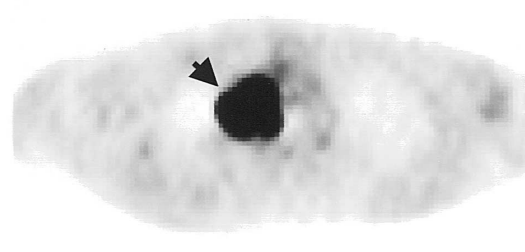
a) Contrast enhanced axial CT scan image at the level of main pulmonary artery bifurcation reveals right hilar adenopathy (*short arrow*). A small hyperdense subcutaneous nodule (*long arrow*) is also present in the right posterior chest wall. b) Corresponding focal intense FDG uptake is seen in both locations on an axial PET scan image (*short and long arrows*). Small chest wall lesions can frequently be overlooked during routine CT scan evaluations, especially in patients with a paucity of fatty tissue that could decrease soft tissue contrast and lesion conspicuity.
